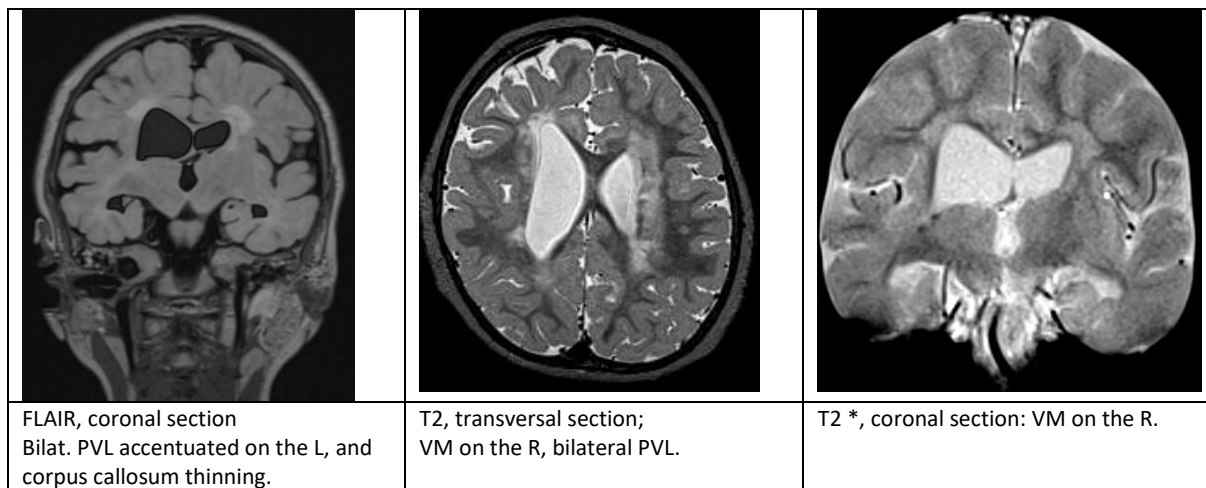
Preoperative MRI, Pat. 2, at age one year and ten months.
